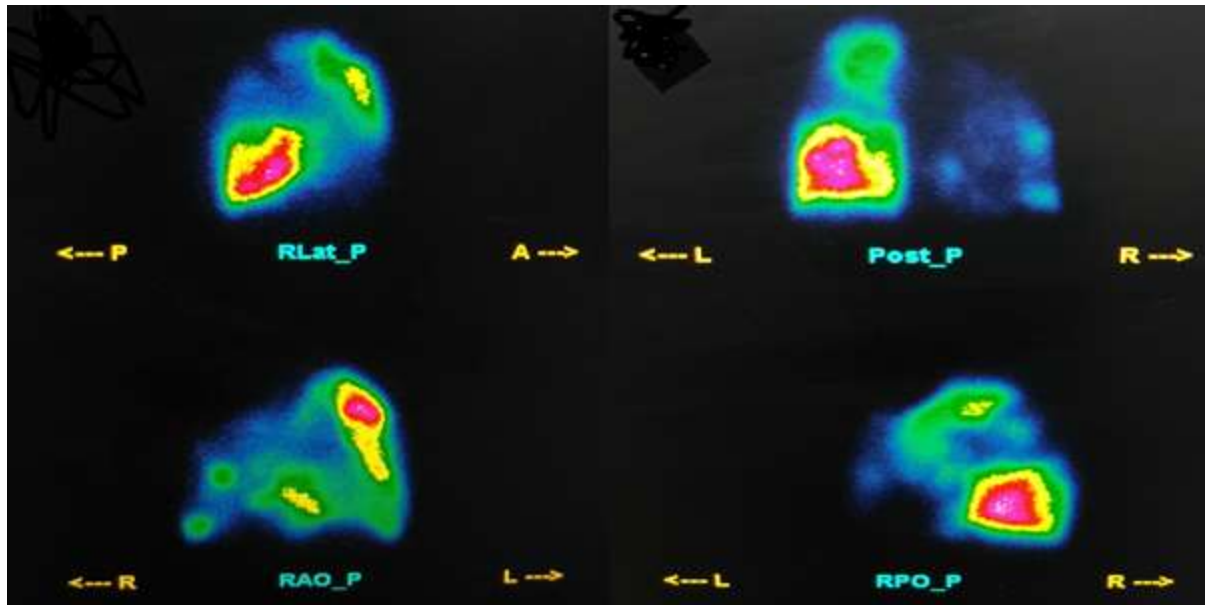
Images of lung scintigraphy showing in the right lung a hypoperfusion of almost the lung parenchyma, more marked in the upper and middle lobe with a systematized perfusion defect in front of the anterior and upper lingual segments of the left upper lobe.
